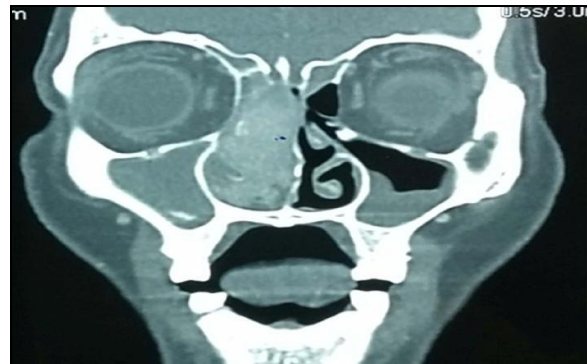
CT-Scan (Coronal cut) showing a large soft tissue enhancing mass that is completely occluding the right nasal passage
